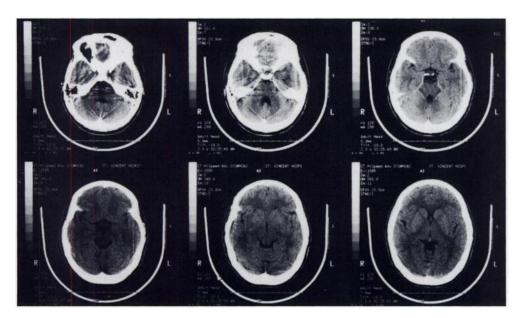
Cerebral CT showing no abnormal findings.
